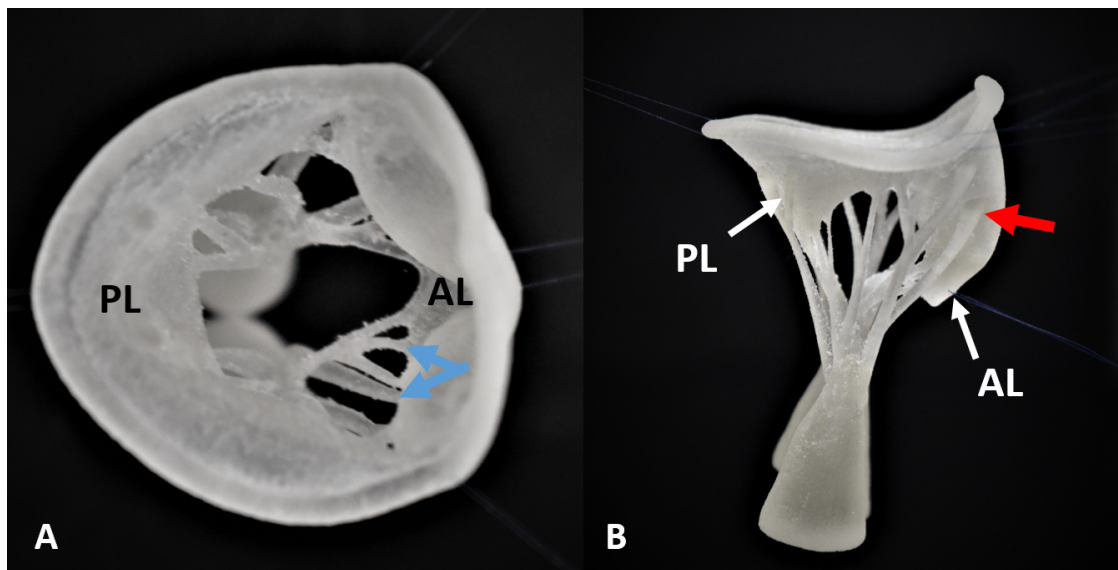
3D-printed mitral valve using high-resolution computed tomography (CT). A: left atrial view of the opened valve. B: lateral view of the open valve. The CT images were used to delineate the leaflet free edges, the precise location of the papillary muscle and the trajectory of the chordae tendinae (1mm thickness). These were then graphically-designed to develop an accurate mitral valve model. Primary (blue arrows) and secondary chords (red arrows) were able to be developed in the model. (AL – anterior leaflet, PL – posterior leaflet)
